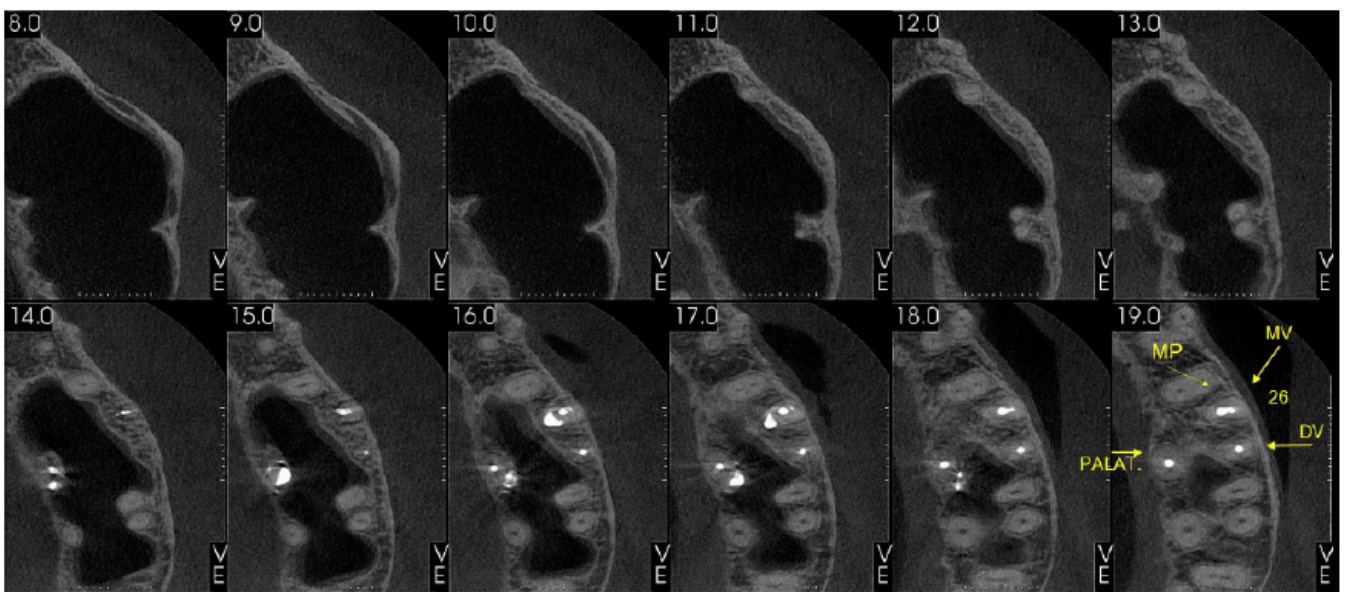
Millimeter-slice CBCT images in the axial plane up to the maxillary sinus region, showing the obturated palatal (P), mesio buccal (MB), mesiopalatal (MP, also referred to as MB2), and distobuccal (DB) canals, and suggesting the absence of a periapical lesion.
